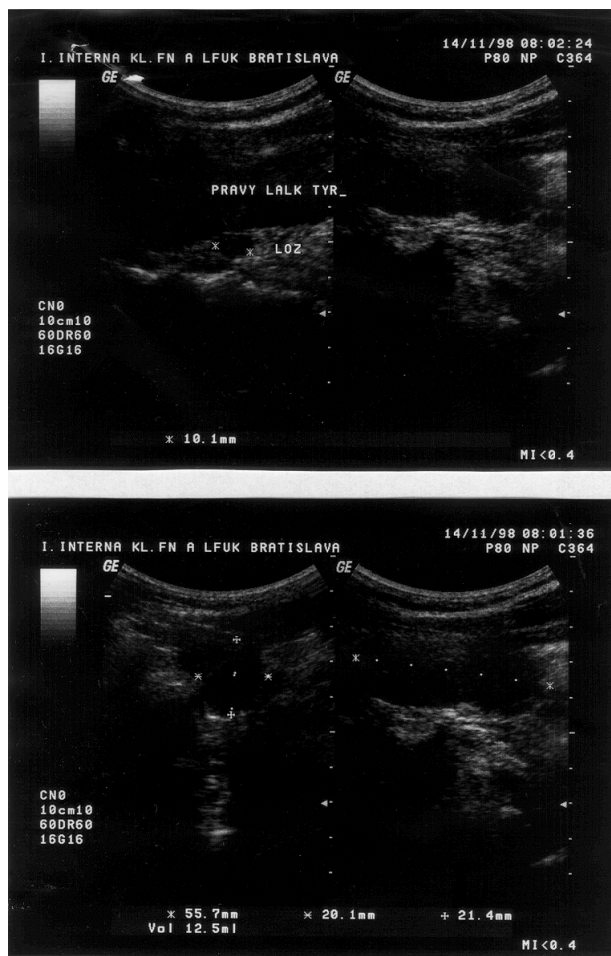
Thyroid ultrasound image. Upper panel – right lobe (LOZ – nodule), lower panel – left lobe.
